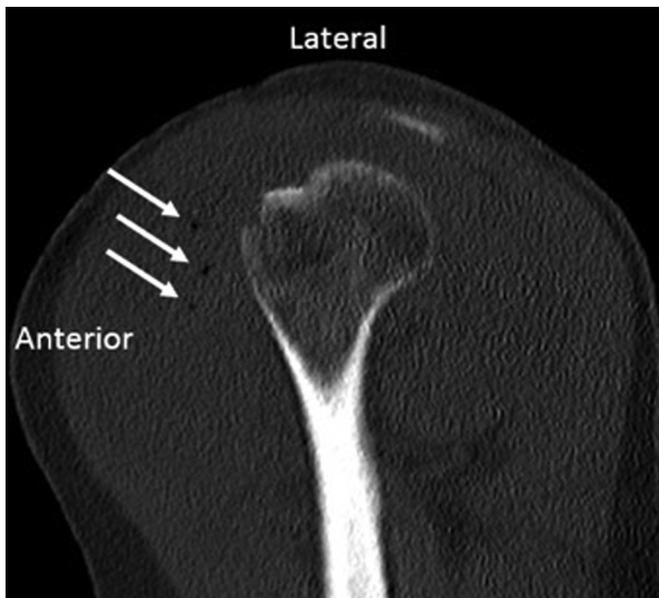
Sagittal CT scan through shoulder with periarticular gas (arrows).
